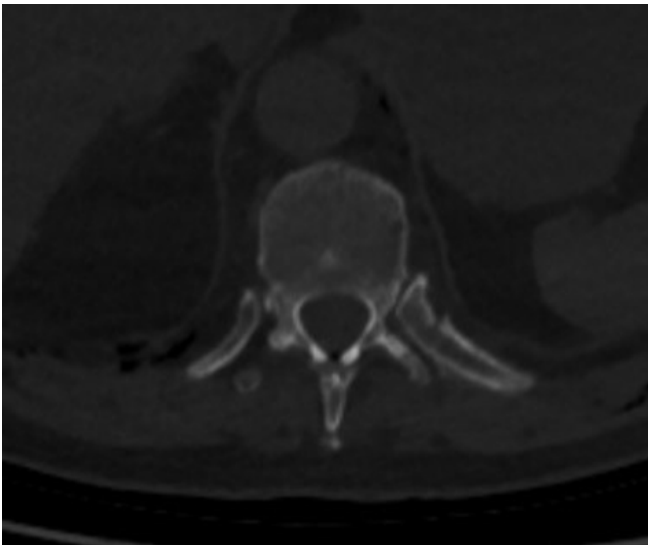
CT scan, axial. Fracture of the left eighth rib without dislocation.
